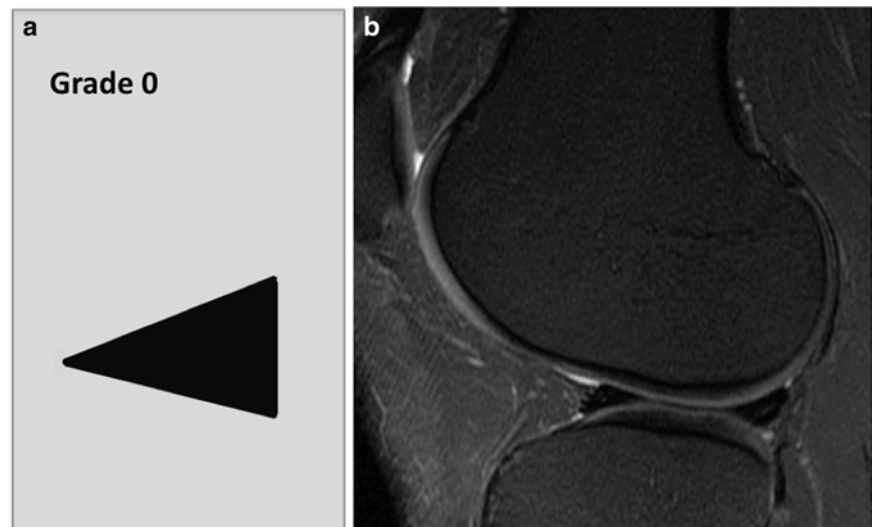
Normal meniscus, Whole-Organ-MRI-Score (WORMS) grade 0. Graph (a) and coronal fat saturated intermediate weighted fast spin echo sequence of the knee (b) showing normal meniscal bodies with no tears and normal shape. Linear focal increases in signal at the lateral meniscus body are consistent with vessels in the red zone*
